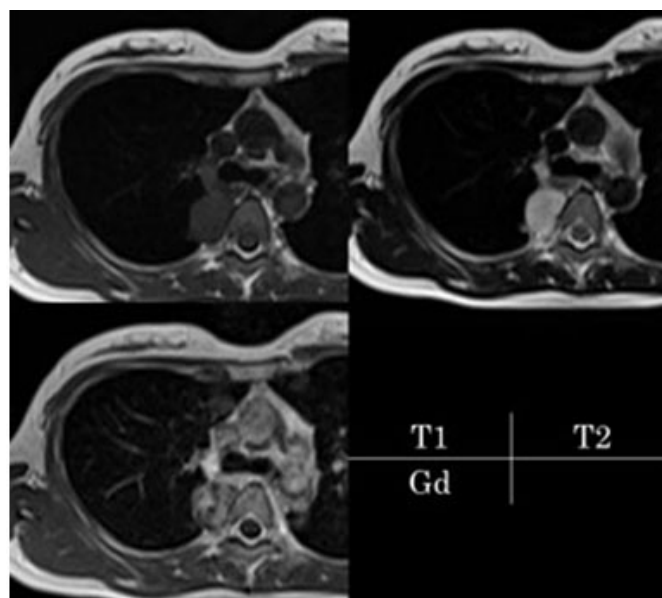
Magnetic resonance imaging in case 1 showing low-signal intensity on T1-weighted imaging, high-signal intensity on T2-weighted imaging, and a heterogenous pattern on gadolinium-enhanced imaging.
